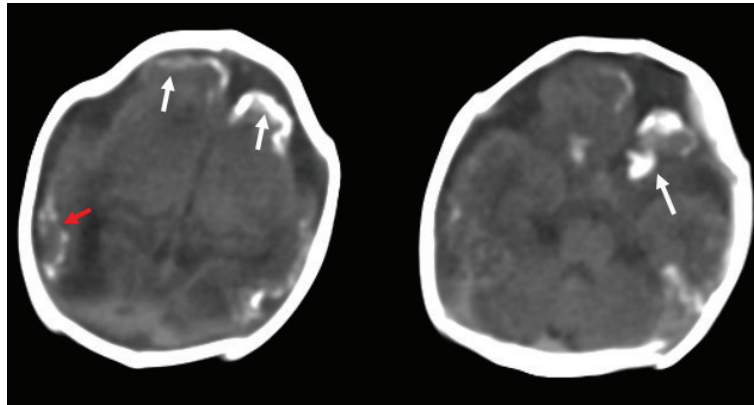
Cranial CT scan showing multiple fine and coarse foci of calcification along sulci (white arrows) and in periventricular white matter (red arrow). Diffuse cerebral atrophy is also evident in the form of prominence of cerebral sulcal, cisternal, and ventricular spaces.
